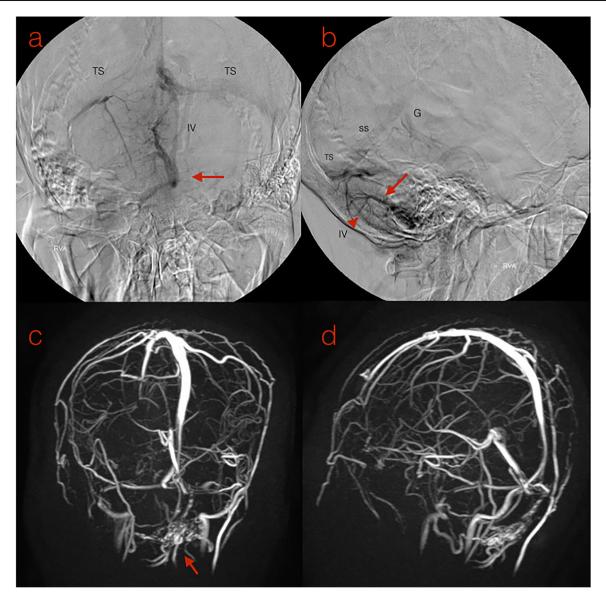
The upper column showed vertebral angiogram, venous phase. The lower column showed magnetic resonance venography (MRV). TS: transverse sinus; IV: inferior vermian vein; SS: straight sinus; G: vein of Galen. (a) AP and (b) lateral. DVA with engorged medullary vein over the floor of fourth ventricle, with collecting vein drain in the inferior vermian vein and further into the straight sinus, with typical caput medusae pattern under vertebral angiogram. (c and d) Three-dimensional reconstructive MRV showed engorged tortuous medullary veins over the floor of fourth ventricle, compatible to previous MRI findings.
